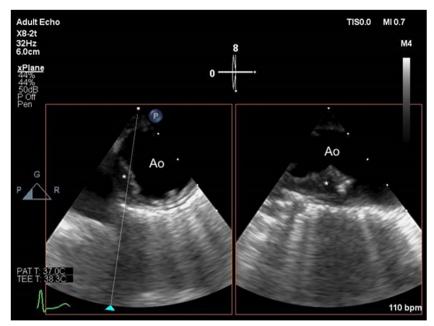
Short and long axis views of the descending aorta obtained by transesophageal echocardiogram, demonstrating a large, mobile and ulcerated atheroma (grade V). Atheroma (*), Ao = Aorta.
